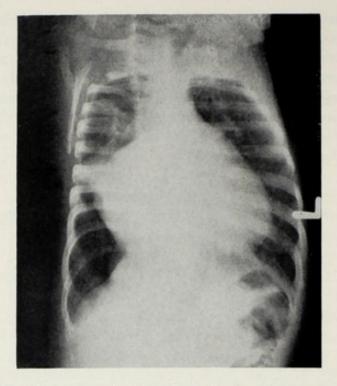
X-ray film of the chest in infant B. J. P. A pulmonary anomaly is evident, as well as pronounced cardiomegaly. B. J. P. (H.L.H. A93754) was born Nov. 9, 1951. She weighed 6 pounds 11 ounces and was
